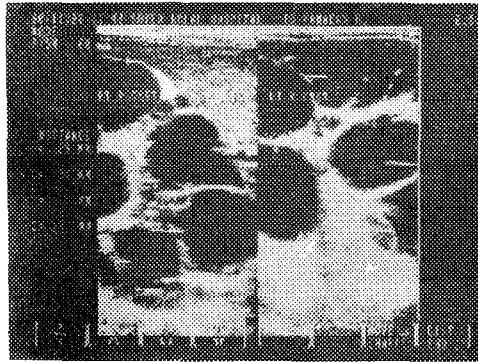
a) Nephrosonography showed both renal parenchyma completely replaced by multiple non communicating transonic cysts.
